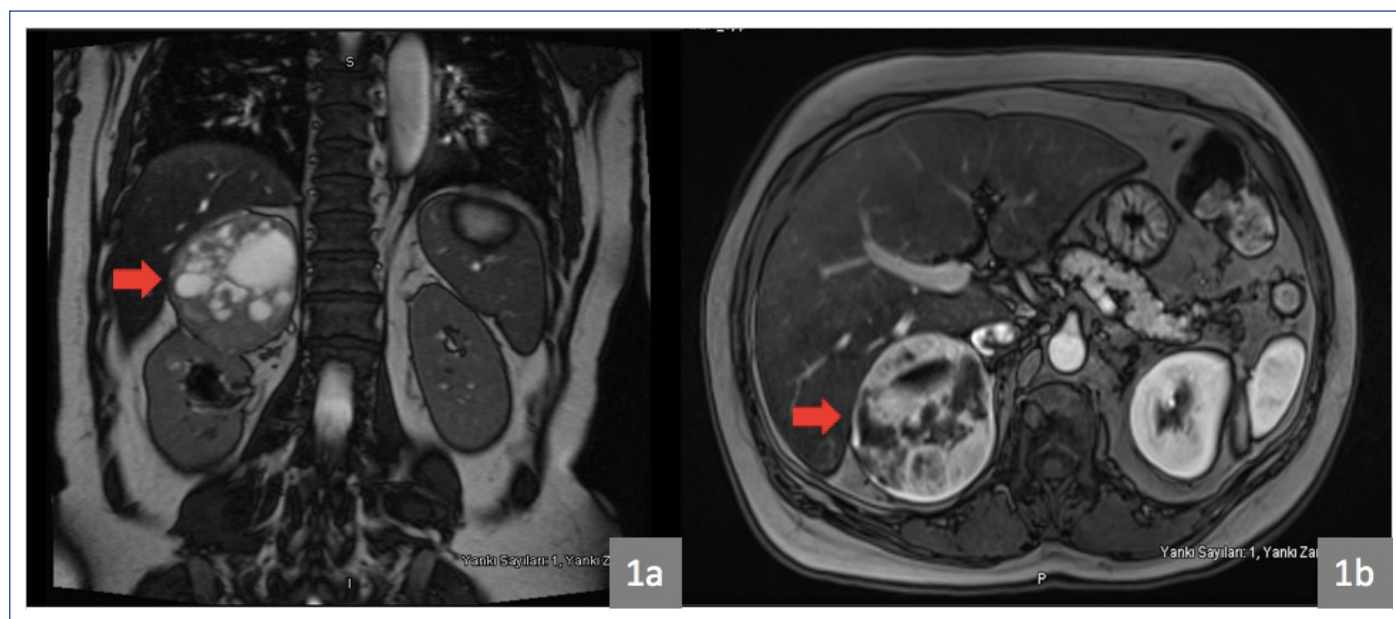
A serious contrast enhancement is observed in the solid areas of the well-circumscribed lesion measuring approximately 75 × 75 × 71 mm, in a heterogeneous structure containing fluid and solid areas suggesting pheochromocytoma. (a) Tumor extension to liver and kidney in T2 coronal series on magnetic resonance imaging. (b) Appearance of the tumor in T1 transverse series.
